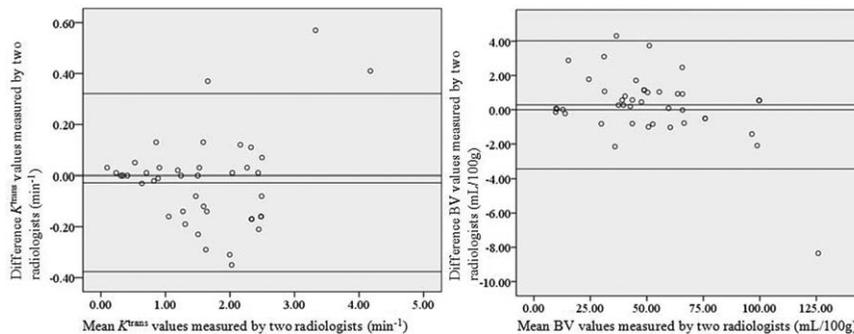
Bland-Altman plots of 2 radiologists' measurements. Bland-Altman 95% limits of agreement in MRI parameters including K^{trans} and BV. Top dotted line shows the upper limit of agreement (mean difference plus 1.96 times standard deviation); bottom line shows a lower limit of agreement (mean difference minus 1.96 times standard deviation). Plots show a possible relationship between 2 radiologists in measurements. BV=blood volume, K^{trans} =vascular transfer constant, MRI=magnetic resonance imaging.
